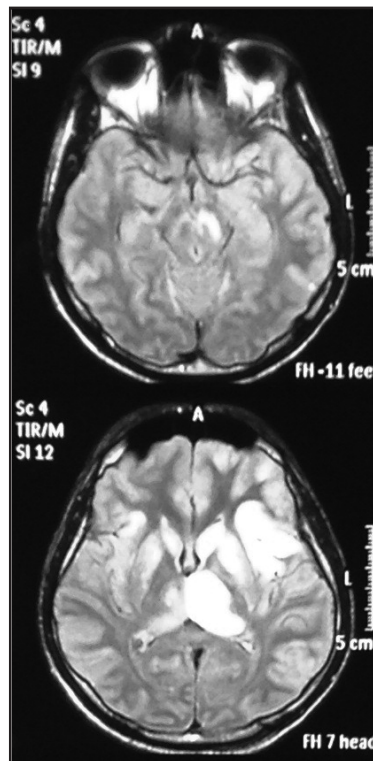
MRI FLAIR sequence showed hyperintensity over bilateral MCA territories involving insula and frontoparietal cortex including bilateral thalamus, bilateral head of caudate nuclei, bilateral lentiform nuclei and left side of midbrain.
